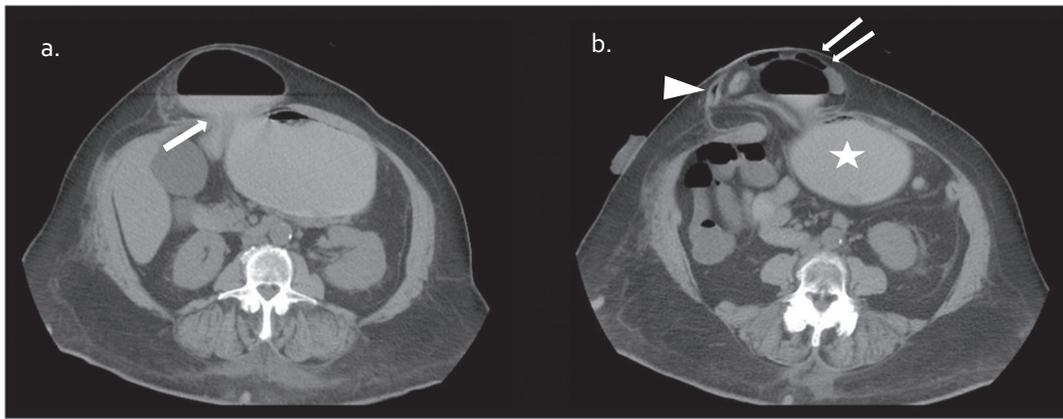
Parastomal hernia with obstruction: axial contrast enhanced CT with incarcerated stomach in a parastomal hernia. Images demonstrate point of obstruction (arrow), distended stomach (star), herniated small bowel (double arrow), and colostomy limb (arrowhead).
